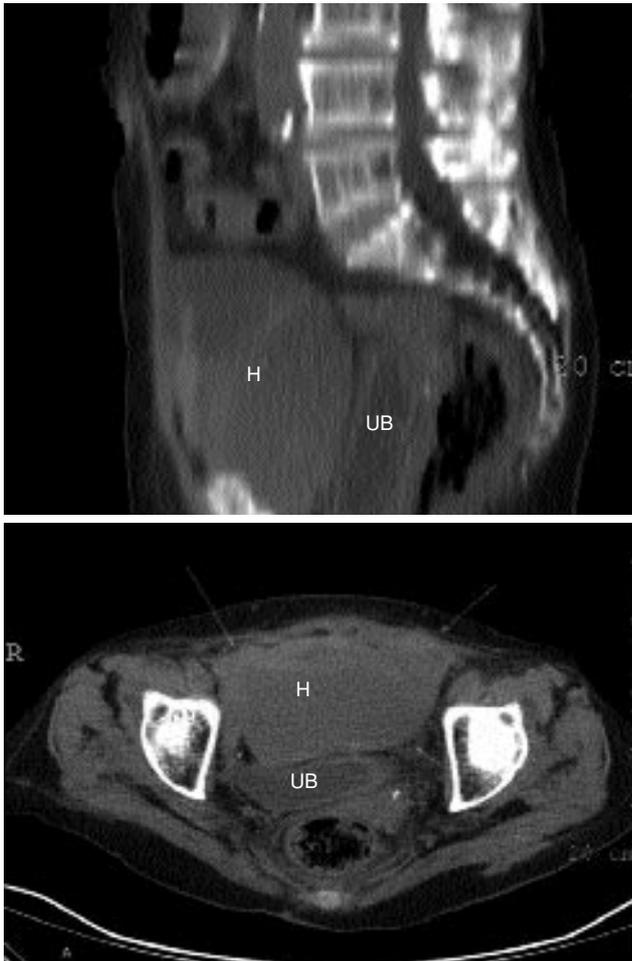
Computed tomography images of the huge intraperitoneal hematoma compressing the bladder. H: Hematoma; UB: Urinary bladder.
